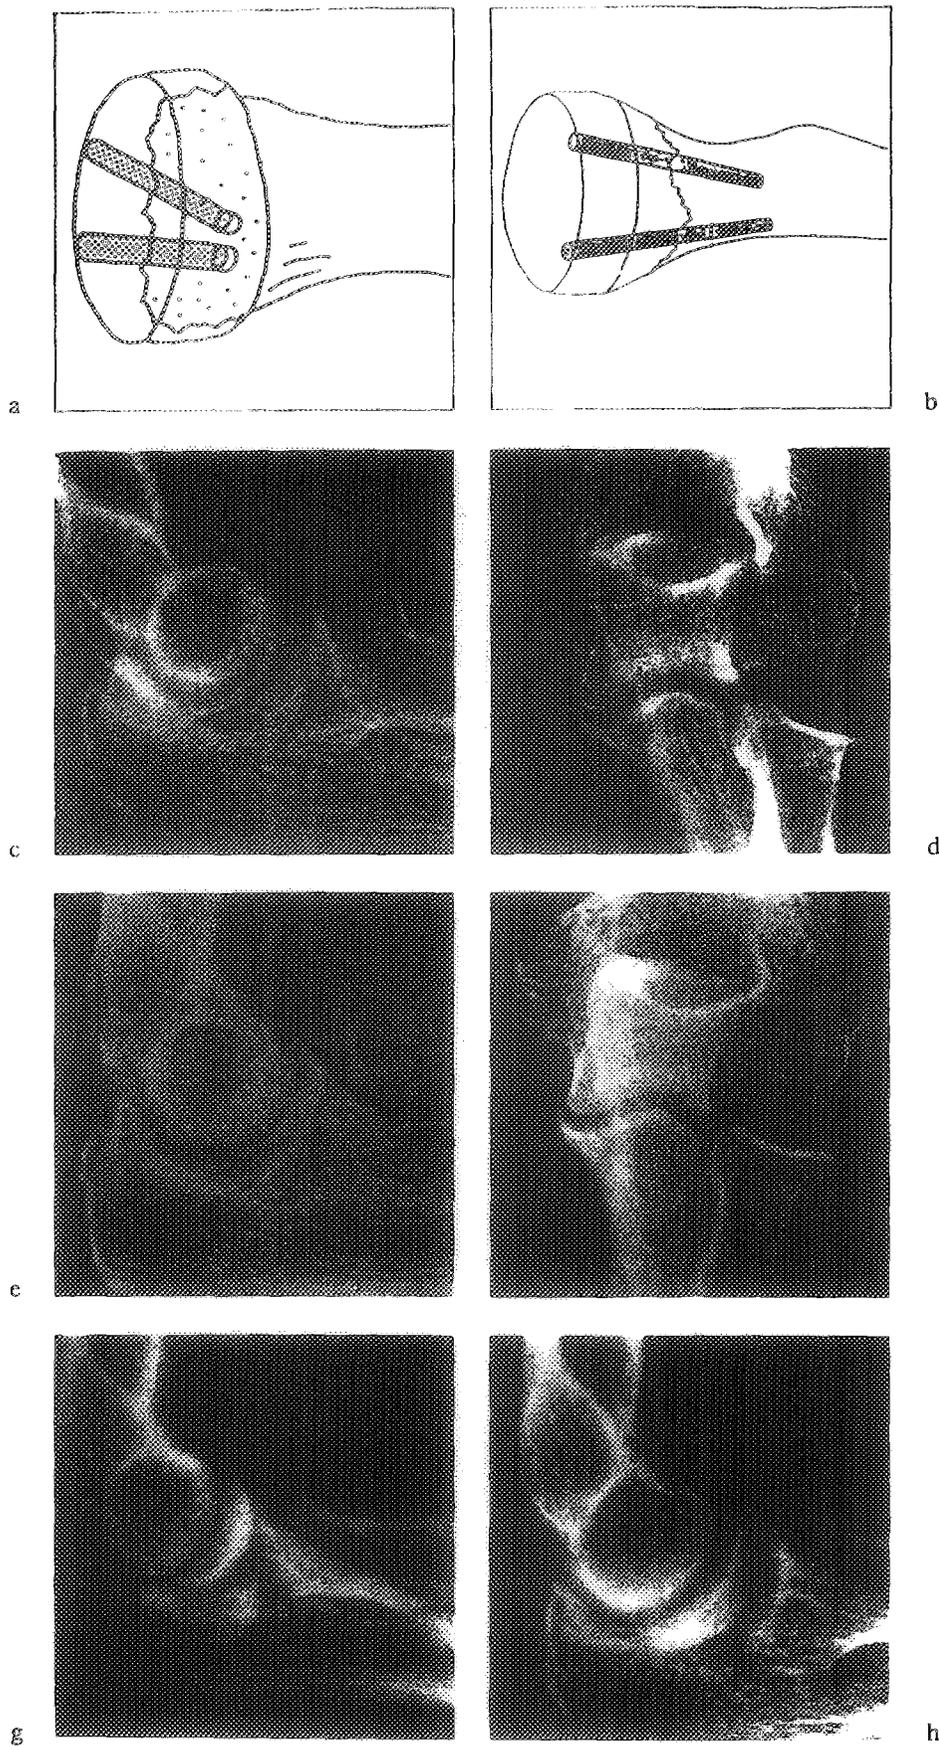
Fixation of marginal fracture of the radial head (a) and of the neck of the radius with a totally displaced radial head (b). Radiograph of a displaced marginal fracture of the radial head seen in lateral and in anteroposterior view on admission (c-d) and as healed one year after fixation with two 2 by 20 mm BIOFIX®-rods (e-f). Radiograph of a totally displaced fracture of the radial neck seen on admission (g) and as healed one year after fixation with two 2 by 30 mm BIOFIX®-rods (h)
